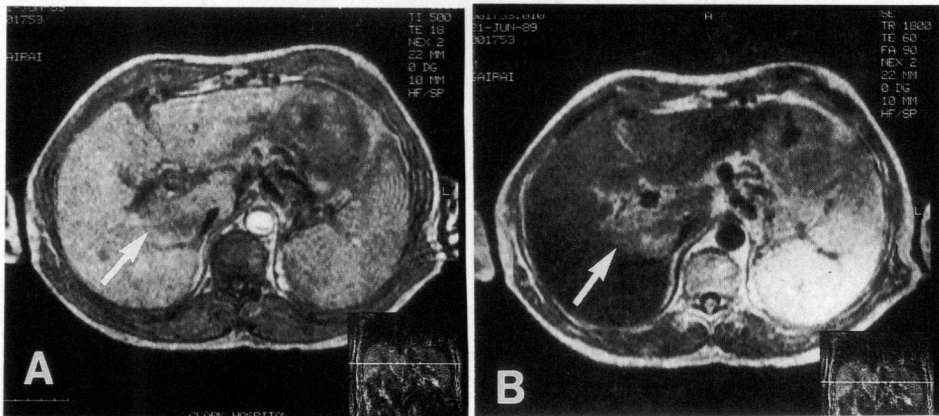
MR imaging of cholangiocellular carcinoma.
